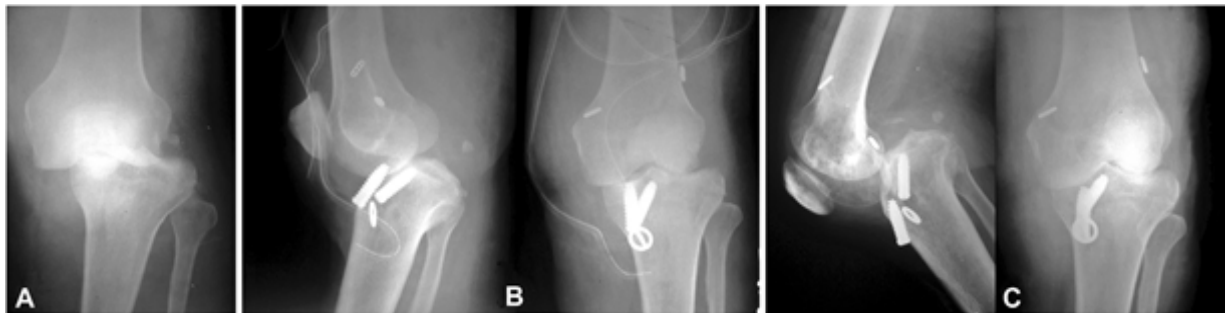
The leading cause of type-2 chronic irreducible knee dislocations is inappropriate primary treatment. Inability to appreciate the complexity of the injury often leads to underdiagnosis and undertreatment of the knee instability. Adequate expertise to manage these injuries, along with early recognition of loss of reduction are critical to avoid overlooking this disastrous complication. (A) Acute posterolateral left knee dislocation in a 29-year-old male. (B) He underwent an inappropriately performed bicruciate reconstruction for his multiple ligament knee injury. His immediate postoperative radiographs revealed a persistently dislocated postsurgical knee. He was subsequently immobilized in this position. (C) Radiographs on presentation to our service 5 months following his primary surgery reveal a Type-2b chronic irreducible left knee dislocation.
